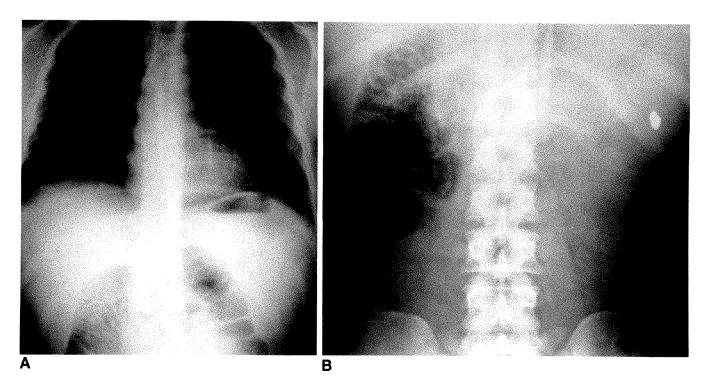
A, Routine chest radiograph made in an asymptomatic posttransplantation patient shows pneumatosis in hepatic flexure of colon. Spleen is mildly enlarged.
